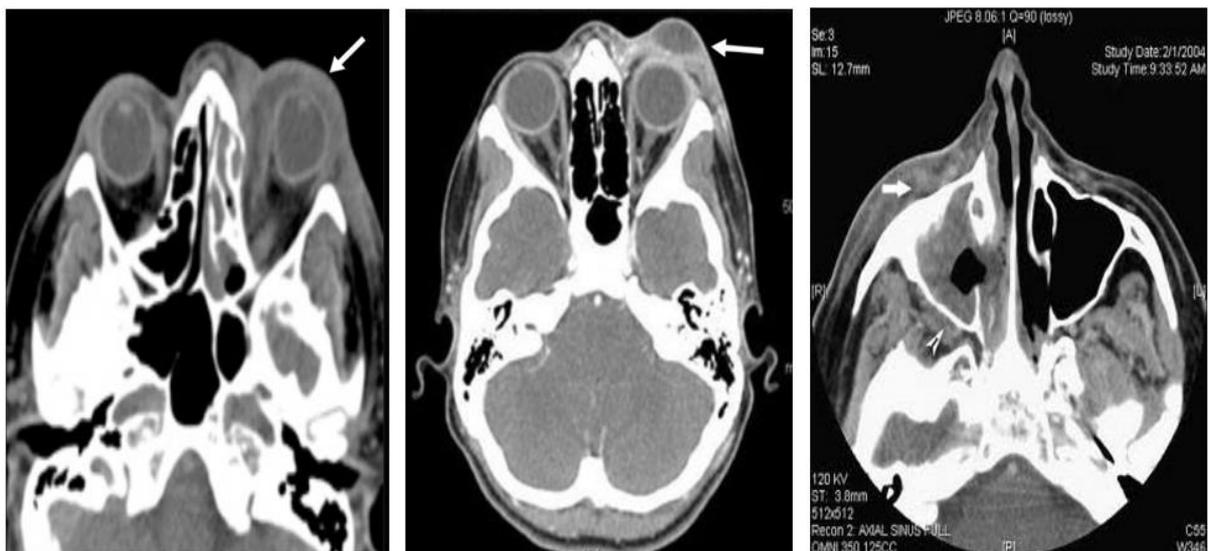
A) Axial plain CT at the level of orbits show left periorbital cellulitis with mild thickening of medial rectus muscle and soft tissue thickening in left ethmoid sinus. Mild proptosis is also noted. B) Contrast CT scan shows left periorbital cellulitis with a
